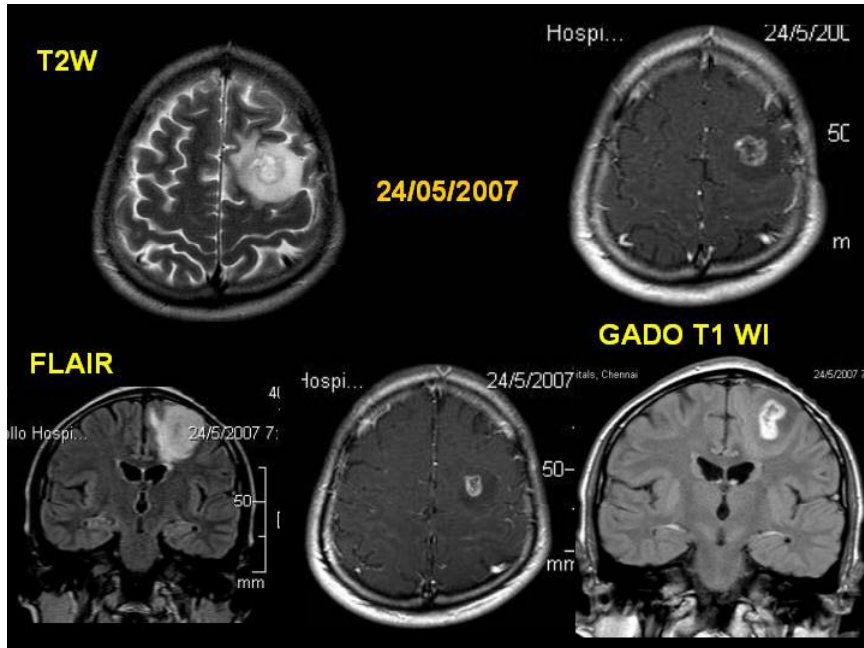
MRI after 3 months shows, a small, nodular, peripheral enhancing lesion with perilesional edema in the left frontal cortex as seen in pre-operative study- Recurrence
